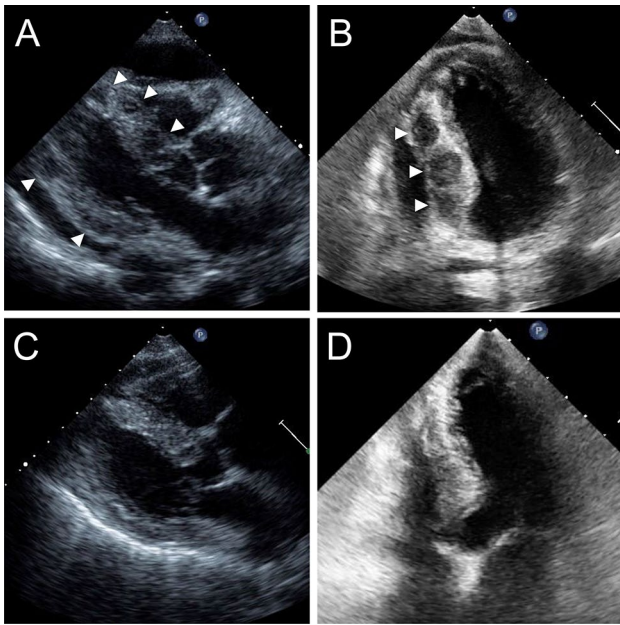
Two-dimensional transthoracic echocardiography images during diastolic phase at admission (a, b) and those after the first course of the chemotherapy (c, d) (a, c, parasternal long-axis view; b, d magnified apical 4-chamber view). a, b Multiple low-echoic nodules (white arrowheads) in the left ventricular wall and moderate amount of pericardial effusion. c, d Disappearance of the intra-left-ventricular-wall nodules and pericardial effusion
